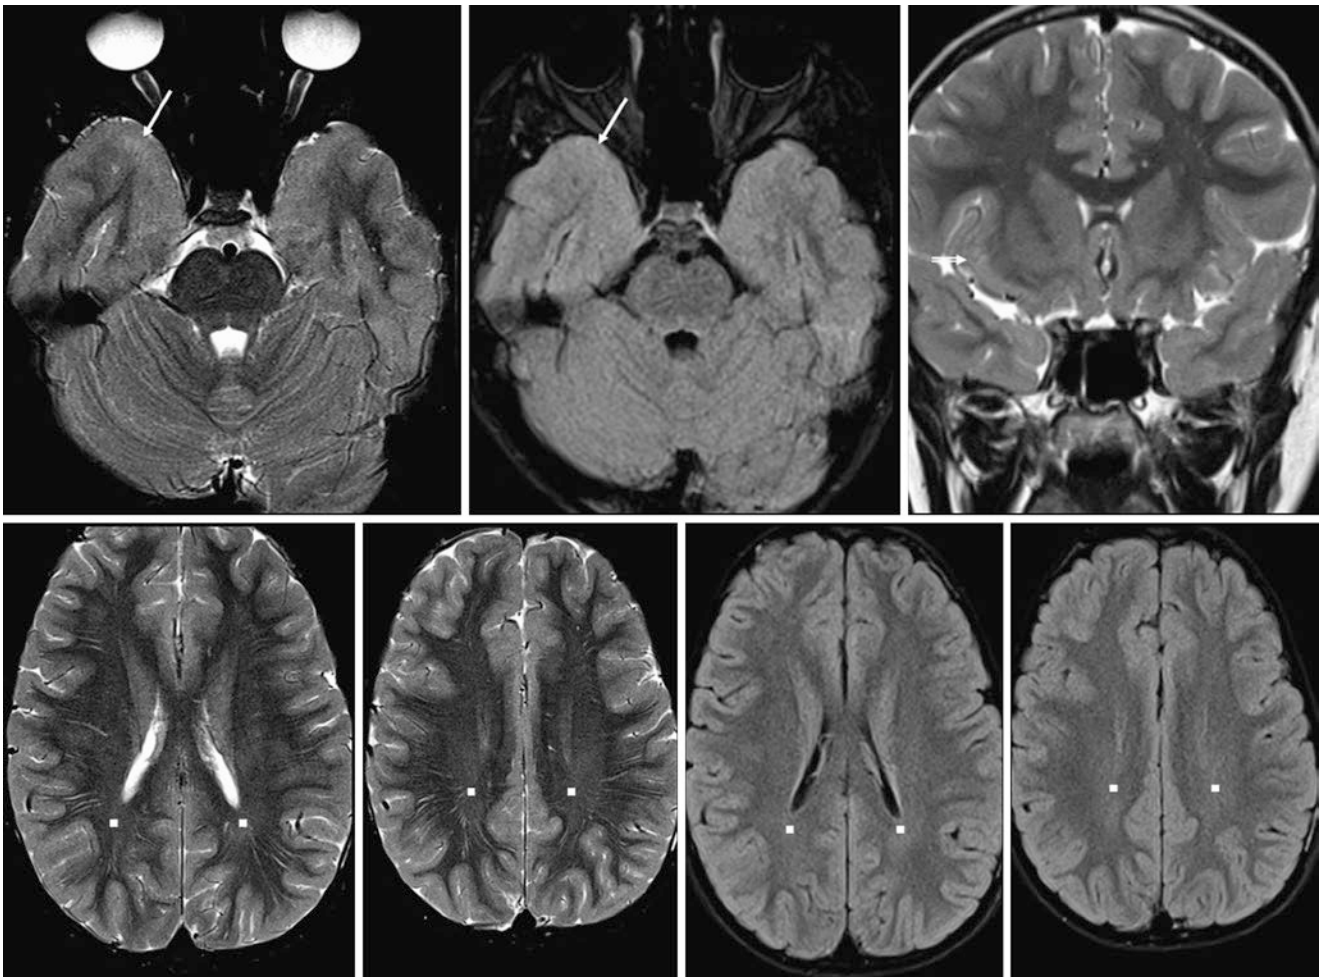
A 10-year-old with chronic headaches had a normal 1.5T MRI. A focal terminal zone (*thin arrows*) is shown within the right ATWM on axial SE T2WIs (*top left*), but is not visible on 2D FLAIR (*top middle*); on coronal T2WI (*top right*), a tiny right SIWM terminal zone is also noted. Axial SE T2WIs (*bottom left*) and FLAIR images (*bottom right*) depict minimal residual PTWM terminal zones (*squares*), as well as many slightly enlarged perivascular spaces in the periaxial WM
